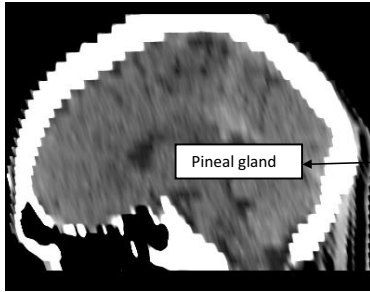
CT scan head-sagittal section.
